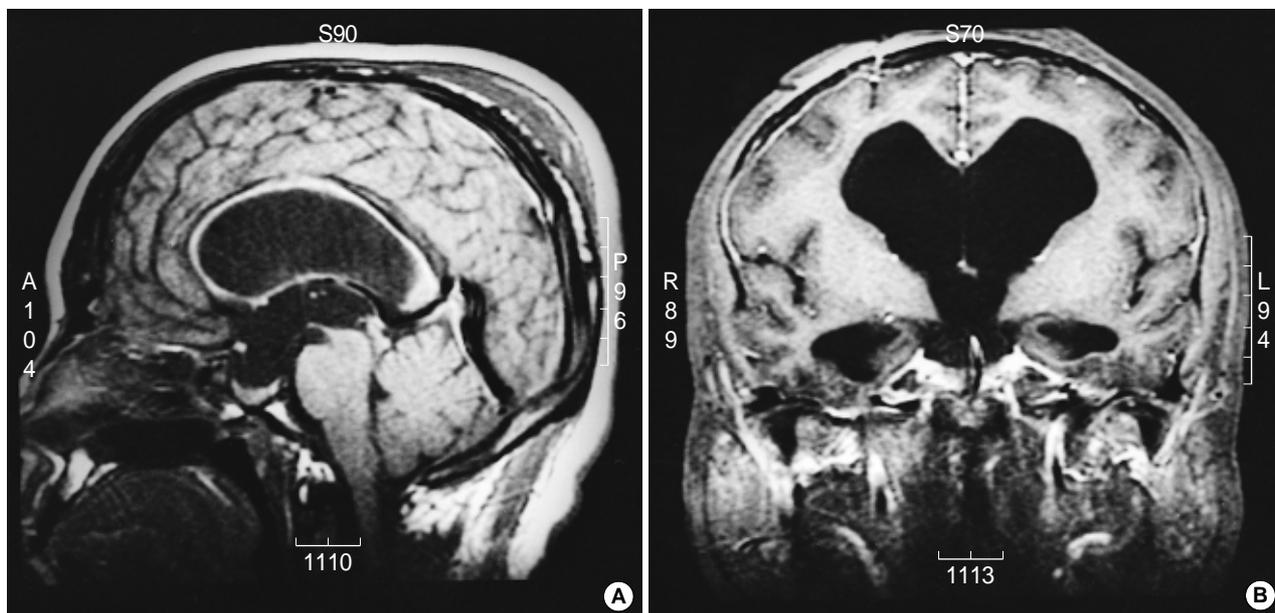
Sagittal T₁-weighted MRI (A) and coronal T₁-weighted MRI after gadolinium administration (B) reveal prominently enlarged third and lateral ventricles with normal fourth ventricle.
